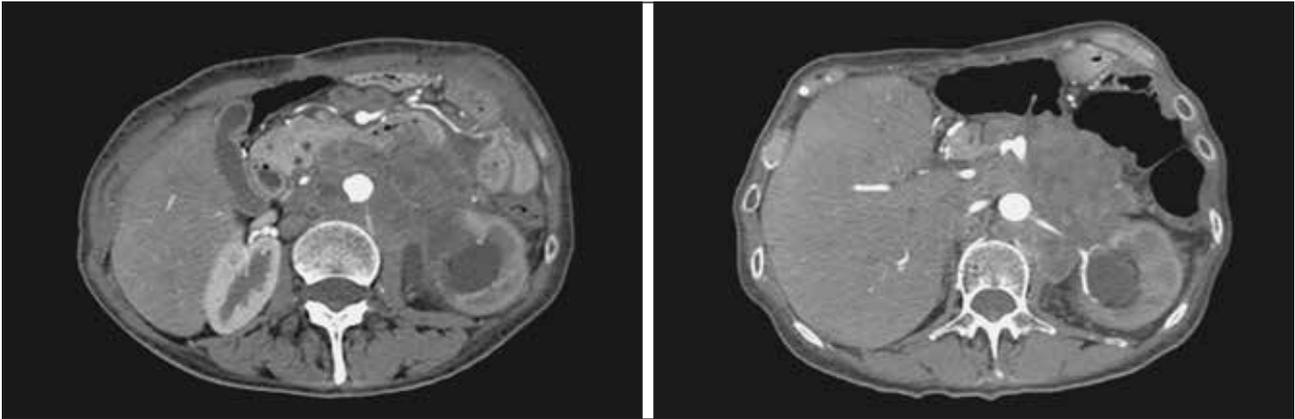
Case 1: Computed tomography scan in an arterial contrast phase, showing invasion of the celiac axis, the left renal artery, and adjacent structures.
